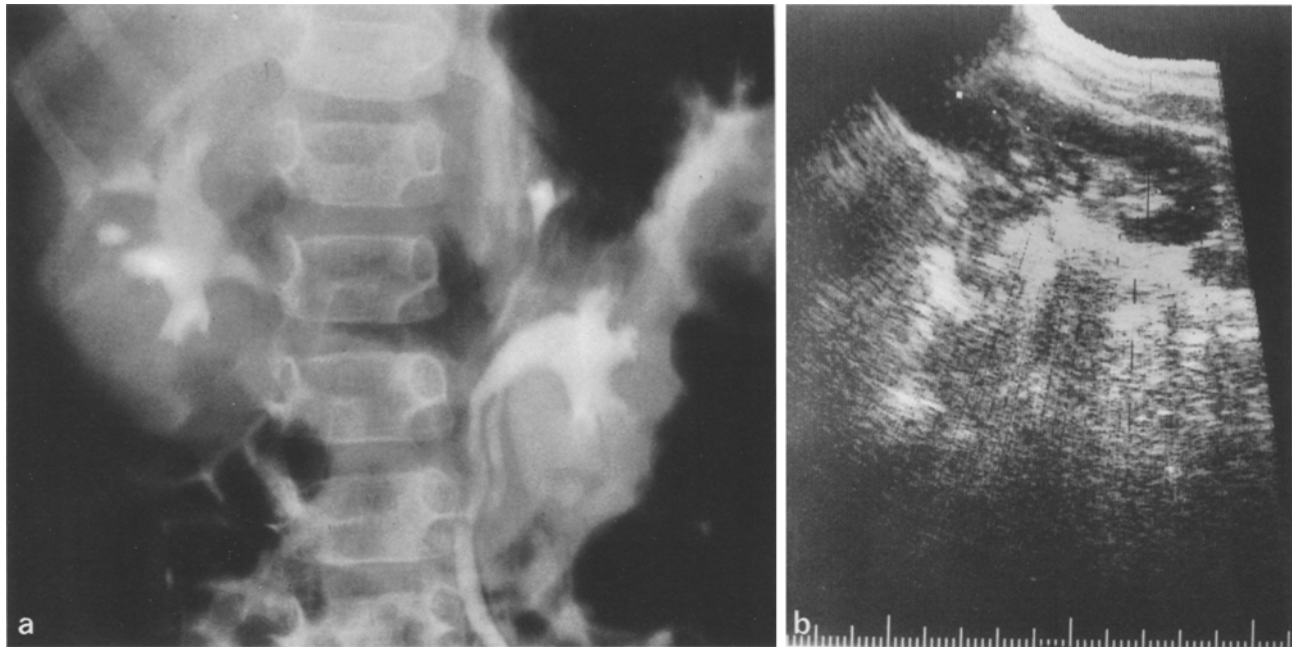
Patient 8. Complete duplication with normal renal sinus. a Left sided duplication on urogram. b Coronal section through left kidney with single sinus echo complex on ultrasound of left kidney. Other views showed a similar pattern in the renal sinus
